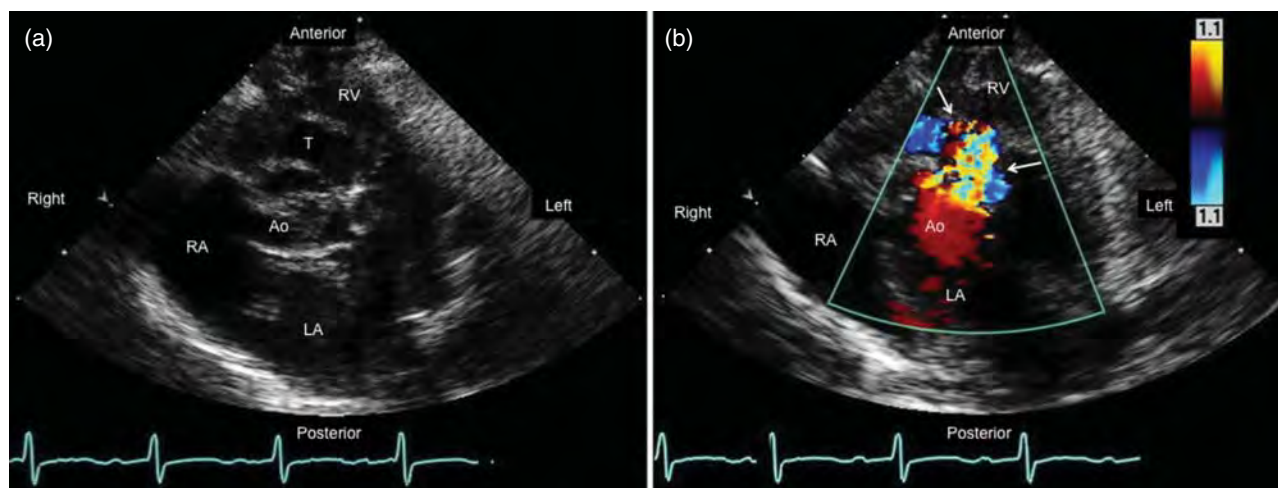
Parasternal short-axis views of a neonate with an aorto-left ventricular tunnel (AoLVT). (a) A two-dimensional anatomic scan and (b) color Doppler image highlights the diastolic flow from the aorta into the tunnel's aortic orifice (arrows). The body of the tunnel lies between the right aortic sinus of Valsalva and the right ventricular outflow tract (RV) and penetrates the upper ventricular septum to empty into the left ventricular outflow tract (out of plane, see Figure 37.1). Ao, aorta; LA, left atrium; RA, right atrium; T, aorto-ventricular tunnel.
